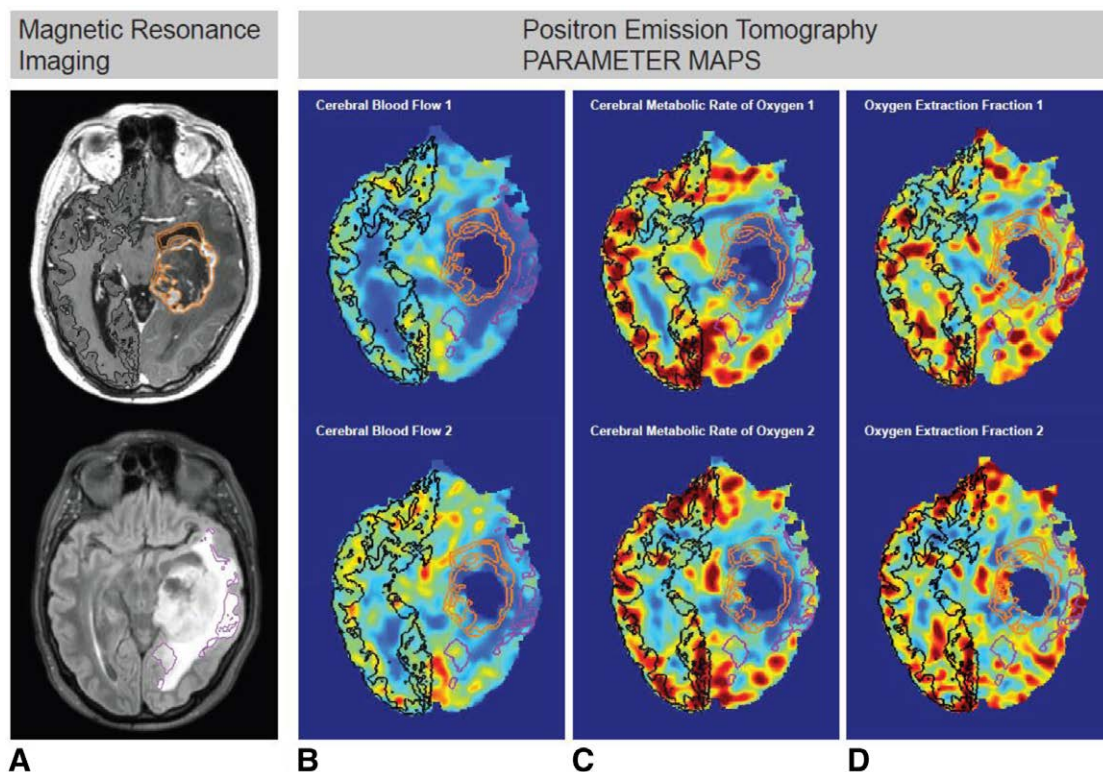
Magnetic resonance and positron emission tomography images of a patient with a tumor in the left hemisphere. (A) The contralateral hemisphere region of interest, tumor region of interest, and peritumoral region of interest were outlined on magnetic resonance images. (B–D) Subsequently, the positron emission tomography parameter maps were coregistered to the magnetic resonance images (color maps of cerebral blood flow, cerebral metabolic rate of oxygen, and oxygen extraction fraction). The contralateral hemisphere is in *black*, the tumor is in *orange*, and the peritumoral area is in *pink*. Cerebral blood flow 1, cerebral metabolic rate of oxygen 1 and oxygen extraction fraction 1 denote the pretreatment conditions, and cerebral blood flow 2, cerebral metabolic rate of oxygen 2 and oxygen extraction fraction 2 denote the posttreatment conditions.
